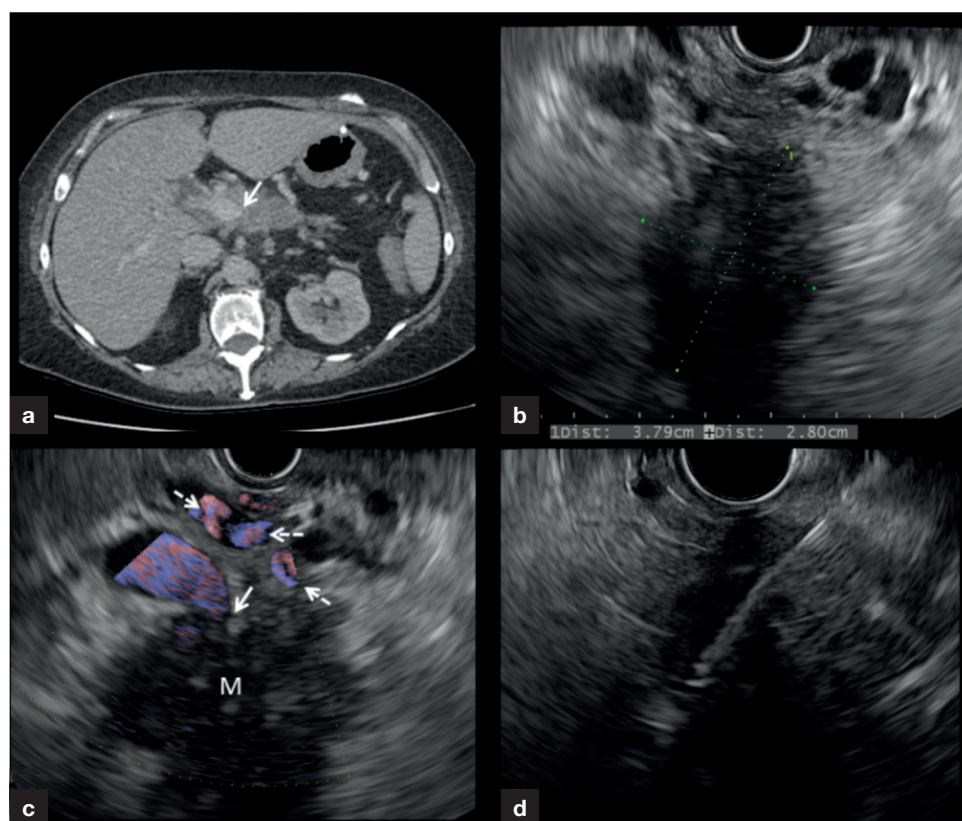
Locally advanced pancreatic ductal adenocarcinoma. a. Computed tomography image showing encasement and invasion of the portal vein (white arrow). b. Endoscopic ultrasound of the pancreatic ductal adenocarcinoma viewed from the gastric antrum. c. Doppler endoscopic ultrasound showing patency but truncation of the portal vein at the superior mesenteric vein/portal confluence (solid white arrow) as a result of local invasion by the pancreatic tumour (M), analogous to the appearance in (a). There is resultant collateral venous distension (dotted white arrows) secondary to occlusion at the portal confluence. d. 22G Echatip fine needle aspiration needle (Cook Medical) sampling the pancreatic ductal adenocarcinoma via the gastric pylorus.
